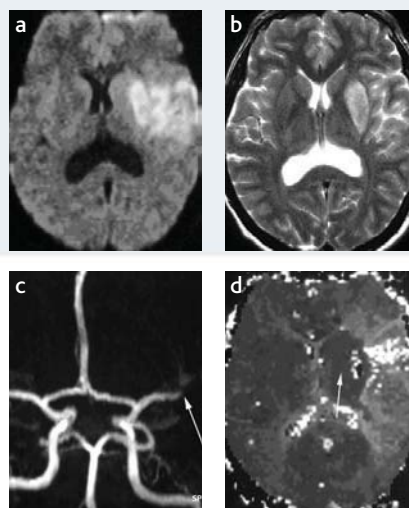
Same patient as in Figure 1. MRI was performed 3 h after CT. On DWI (2a), an almost identical region to that demonstrated with CT shows increased signal. On T2-weighted spin echo sequences (2b), the signal is increased within the lentiform nucleus and the insular cortex. The time-of-flight MR angiography (2c) shows an occlusion of the distal MCA trunk (arrow) resulting in a perfusion deficit on the time-to-peak-parameter map (2d). Remarkably, the left lentiform nucleus (arrow) appears as already hyper-perfused at this timepoint.
